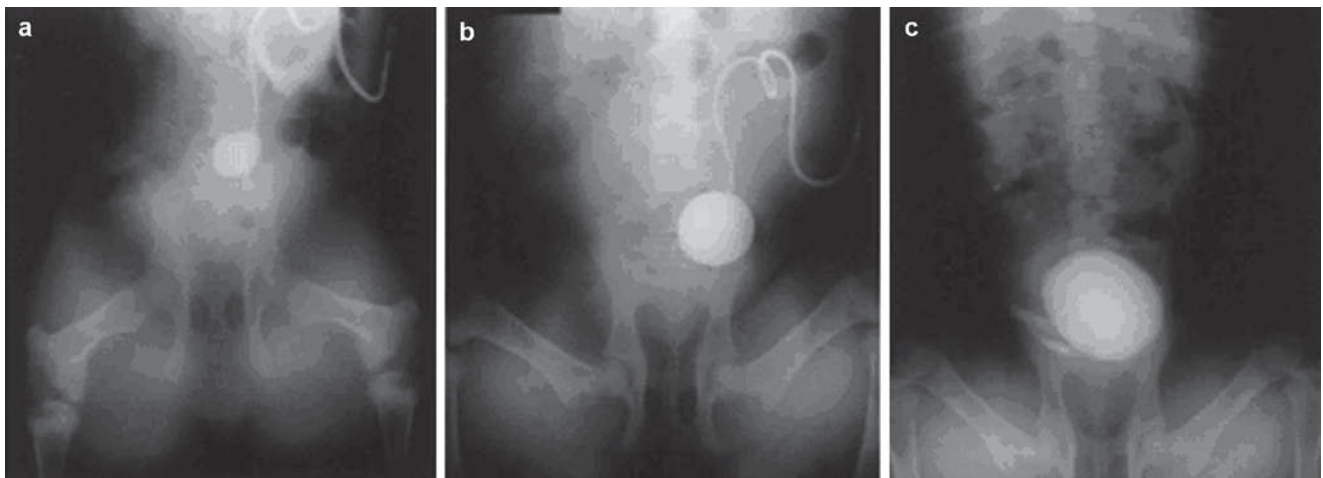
Plain radiographs of the abdomen document progressive ureteral expansion (a) At 1 week with 12 mL volume. (b) At 2 week, volume in balloon has increased to 46 mL. (c) At 25 days just prior to augmentation ureterocystoplasty with 140 mL in the balloon
